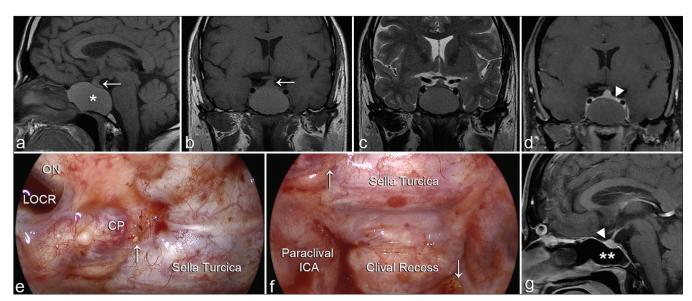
Isolated sphenoid sinus fungal mucocele (Case No. 4). (a-d) Preoperative magnetic resonance imaging (MRI) reveals an expansile sphenoid sinus mass (an asterisk) that displays a slightly hyperintense signal on T1-weighted (a and b), and (c) an isointense signal on T2-weighted MRI. (d) No enhancement is seen after contrast injection. Compression of the pituitary gland (a and b arrows, d arrowhead) is notable due to the mass effect of the mucocele. (e-f) Intraoperative views during mucocele marsupialization and drainage through an endoscopic endonasal transsphenoidal sphenoidectomy. Anatomical landmarks within the sphenoid sinus are seen. Yellow tiny fungal material is seen attached to the walls (arrows). (g) Postoperative sagittal T1-weighted MRI with contrast demonstrating full decompression of the mucocele and evacuation of its contents (double asterisks). The decompressed pituitary gland is seen (arrowhead). CP: Carotid prominence, LOCR: Lateral optico-carotid recess, ON: Optic nerve.
